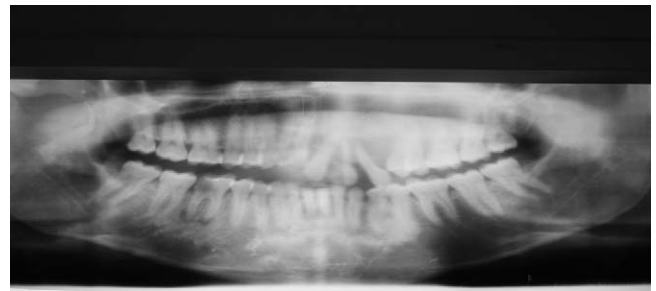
Orthopantomogram showing teeth 21, 22, and 23 pushed by the tumoral process.
